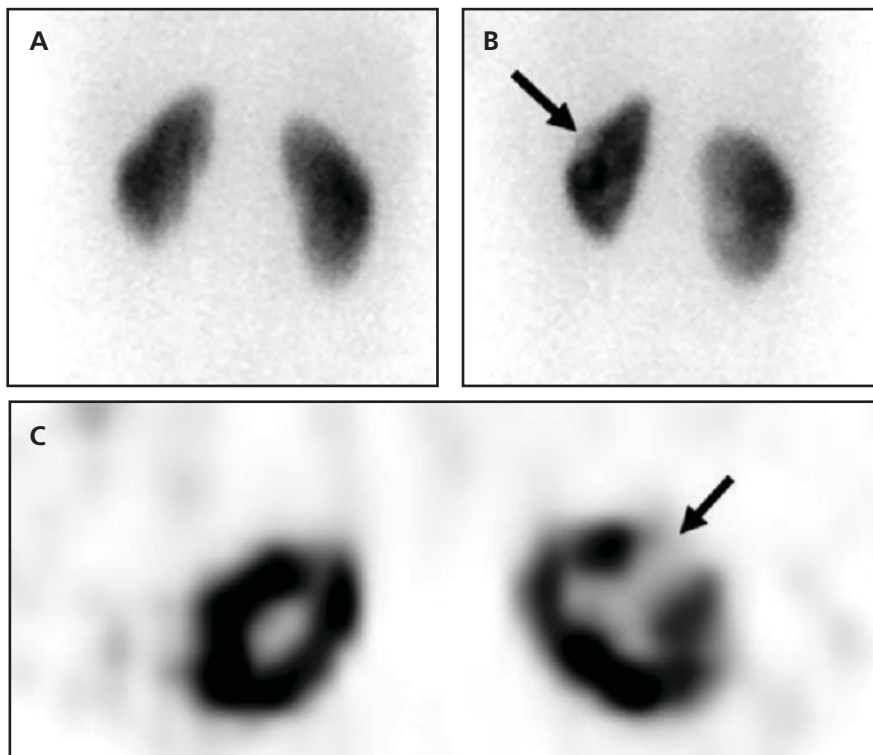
Scarring on renal cortical imaging. Posterior, LPO, and transverse SPECT image from a Tc-99m DMSA renal scan demonstrates a wedge-shaped cortical defect in the mid to upper left kidney. This correlated with a region of cortical scarring on CT.
